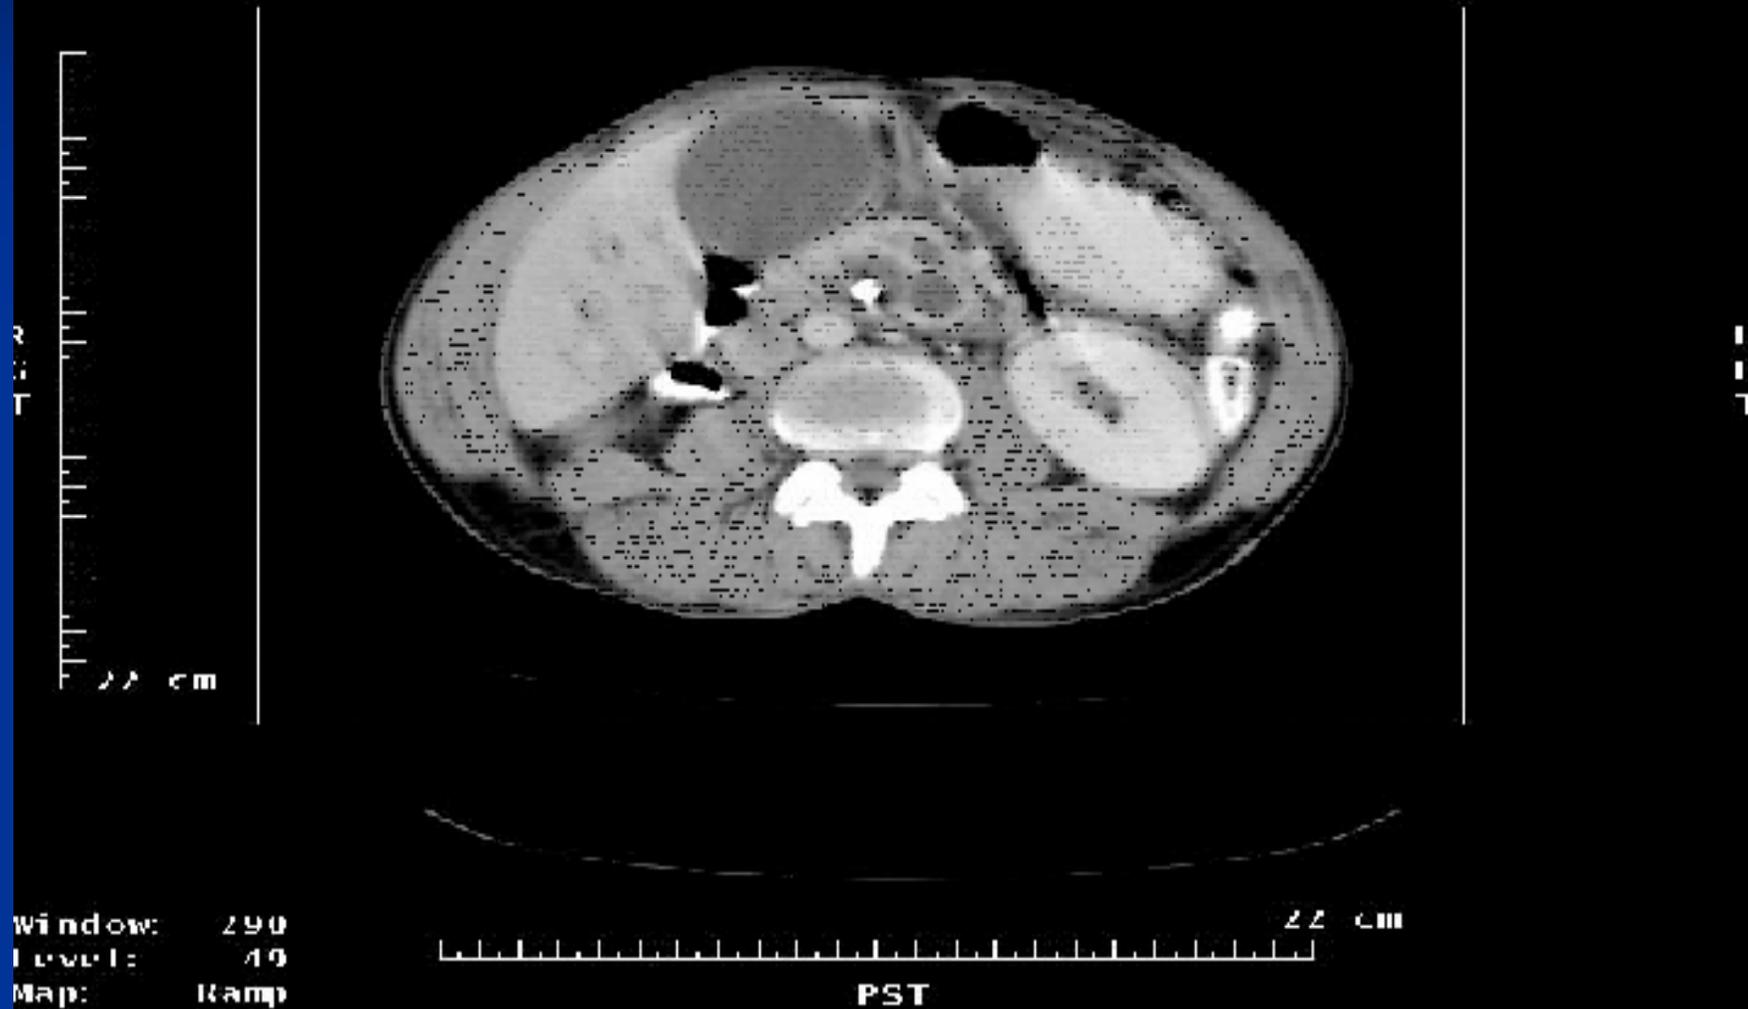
preoperative CT with pancreatic head mass and visible stent
